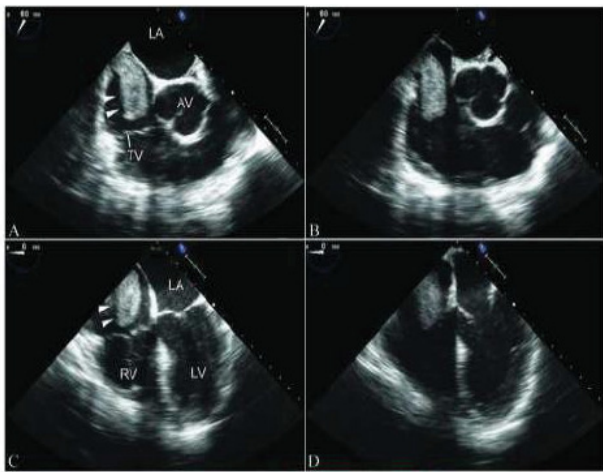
Echocardiogram showing RA thrombus from IVC into RA across Tricuspid Valve.
